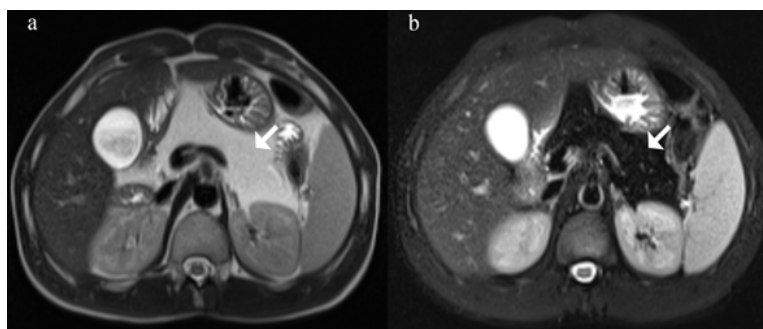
MR T2-weighted images without (a) and with fat suppression (b) show pancreatic enlargement (arrows), with loss of the normal pancreatic lobular contour and complete fatty replacement. The pancreatic signal intensity is similar to that of the retroperitoneal fat.
